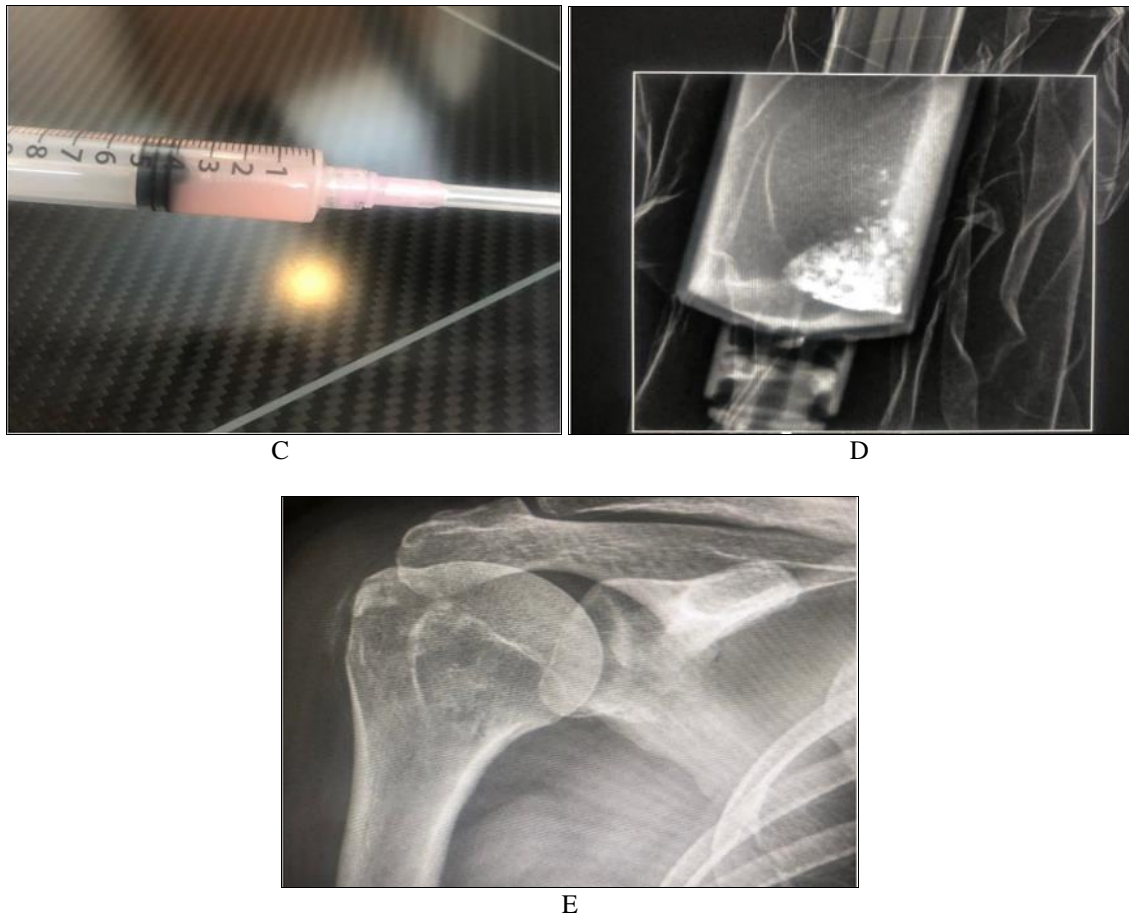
Ultrasound (US)-guided barbotage case of supraspinatus calcified tendinitis (A) Supraspinatus calcified tendinitis, (B) US-guided barbotage, (C) Aspirated calcium using two 18 gauge needles, saline after local anesthesia, (D) X ray of the aspirated calcium, (E) Post-barbotage with disappearance of the calcium.
